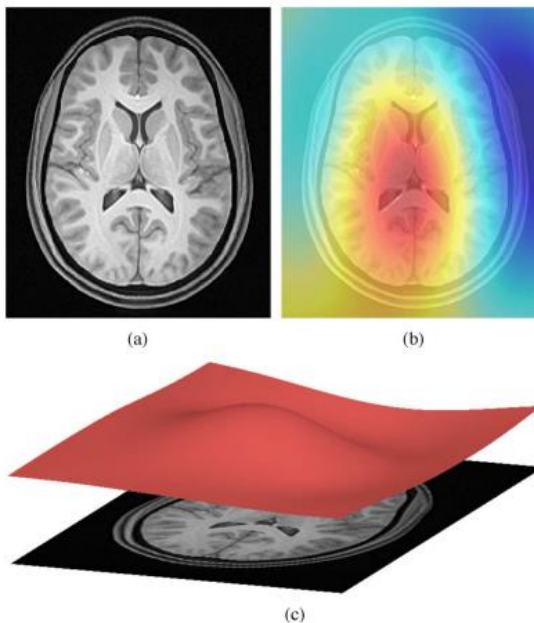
[241] (a) T1-weighted MR image exhibiting bias, (b) Estimation of the bias field which can then be used to correct the image, (c) Viewed as a surface, the low frequency modulation of the bias field.
